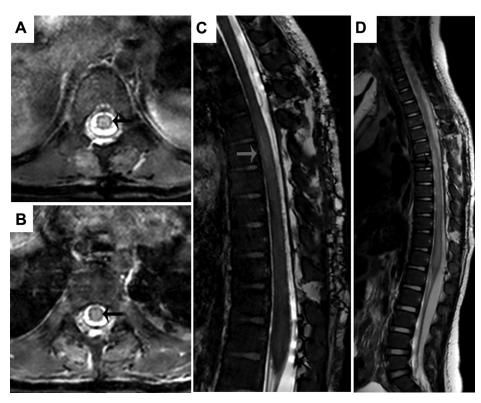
Axial (A, B) and sagittal (C, D) postoperative T-2 weighted MR images demonstrate excellent decompression of the dorsal fluid collection with restoration of circumferential CSF signal around the spinal cord (Black/gray arrow). Progression of cord edema is noted.
